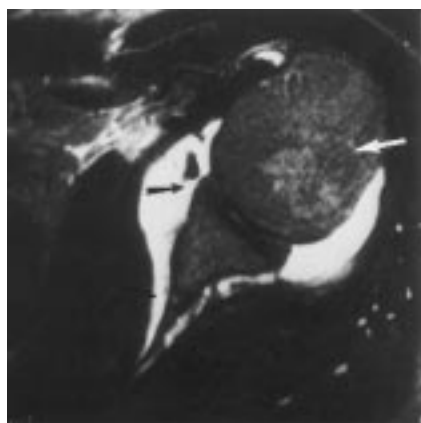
An axial T2-weighted magnetic resonance image obtained after an acute primary dislocation. White arrow indicates marrow edema (Hill-Sachs lesion). Black arrows indicate an anterior labral tear with capsular stripping along the glenoid neck (Bankart lesion).
